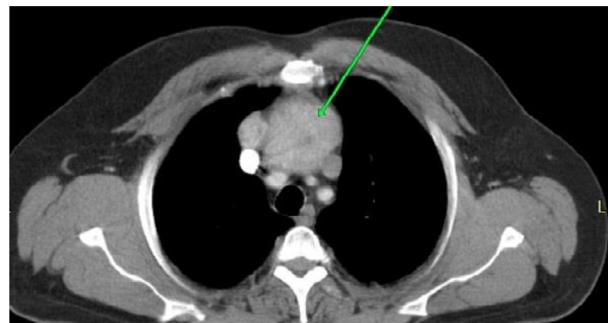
Contrast CT scan of the thorax shows marked contrast enhancement of the midline anterior mediastinal mass (arrow).
